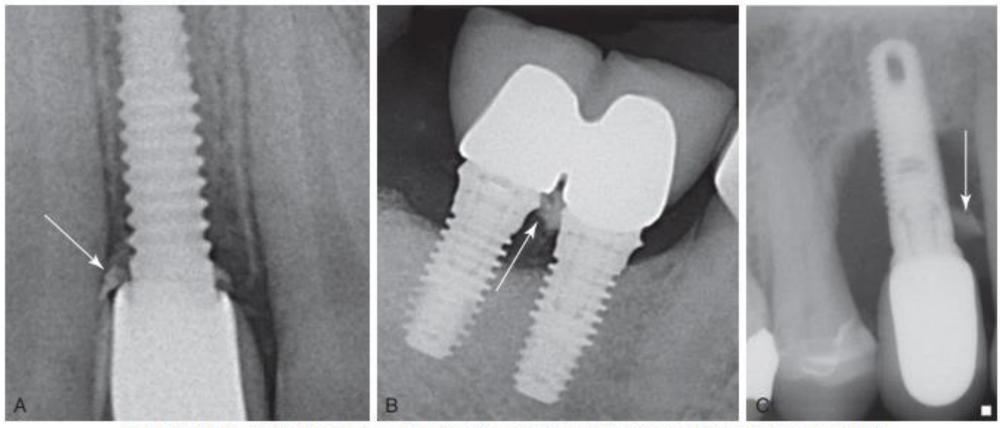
(A-C) Radiographic evaluation of cement retention; can only be seen on mesial and distal.
